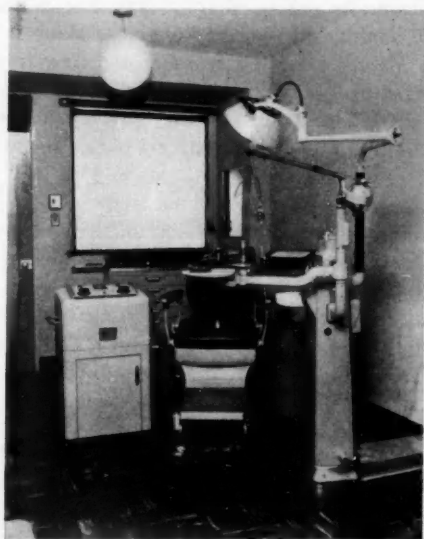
Special techniques room, College of Dentistry, The Ohio State University. Ultrasonic unit in operating position at chair.
